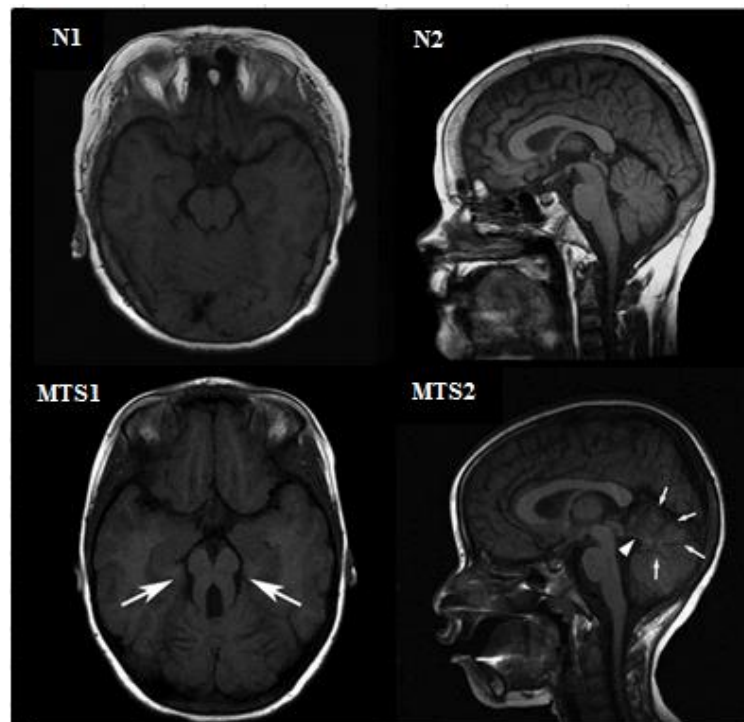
Cerebral MRI of a normal cerebellar vermis and Molar Tooth Sign
